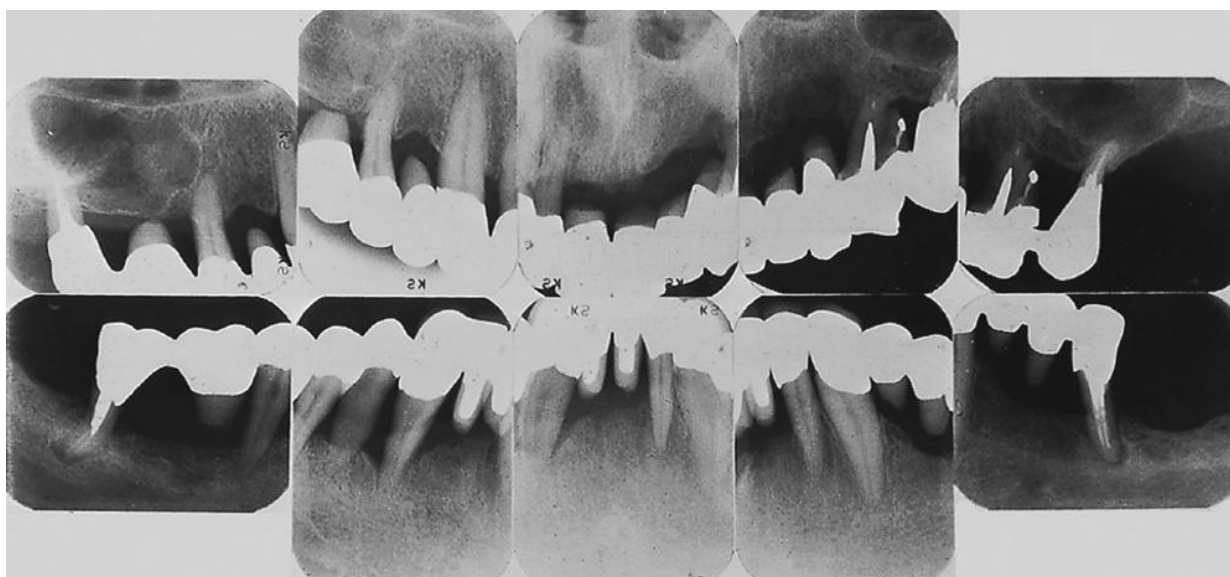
Case B. Radiographs obtained 10 years after therapy.
